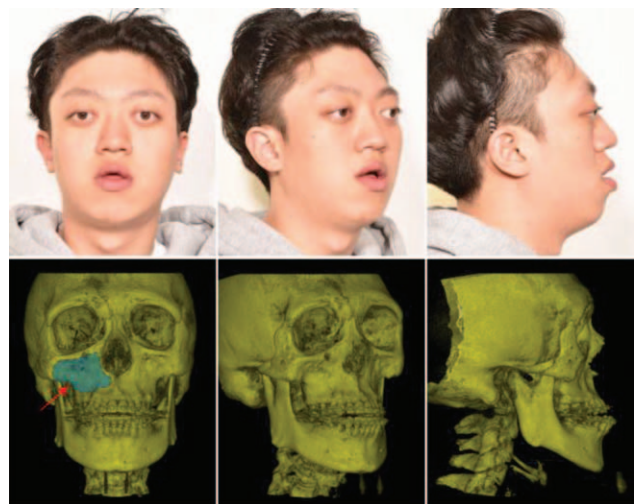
Facial photographs and radiographs taken after preoperative orthodontic treatment (physical growth completed state). The patient is diagnosed with Crouzon syndrome and shows only mild symptoms. Extensive midface deficiency is recognized from clinical photos and CBCT images (red arrow). CBCT, cone-beam computed tomography.
